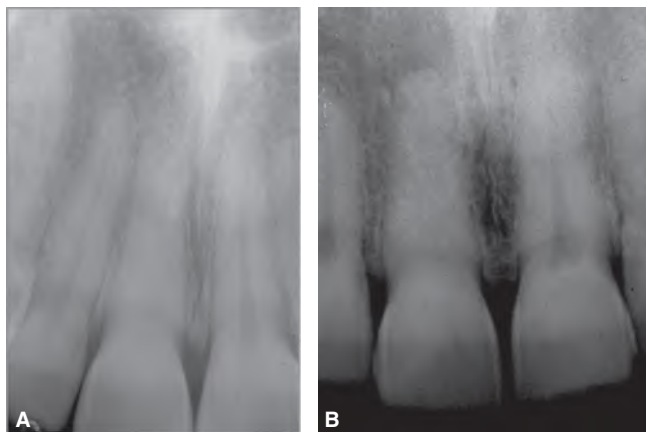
A. The maxillary right central incisor has pulp canal calcification. There was no response to CO₂ and electric pulp testing but there are no radiographic signs of any periapical changes; hence, there are no signs of the root canal system being infected and no treatment is required. B. The maxillary right central incisor has pulp canal calcification with a pulpless and infected root canal system and chronic apical periodontitis as a result of trauma 22 years previously.
